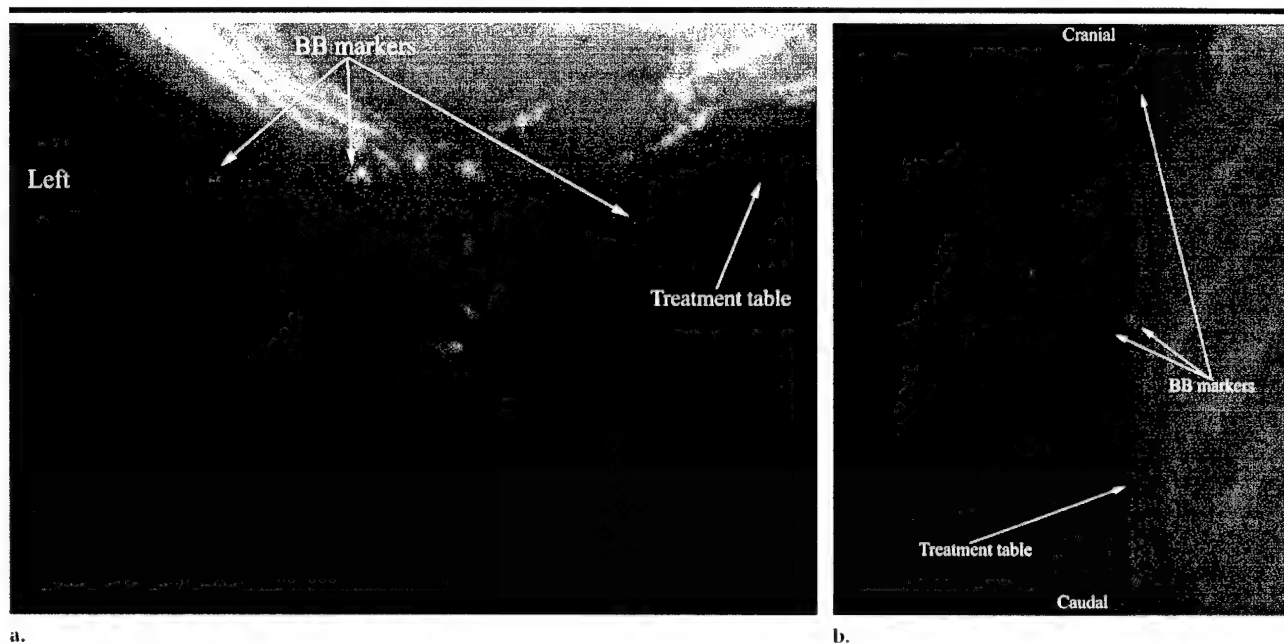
Example in patient 9, who had a lesion suitable for treatment with the proposed technique. (a) Transverse and (b) sagittal digital radiographic reconstructions show clips in the patient's breast that were used to identify a volume that clears the projection of the treatment table.
